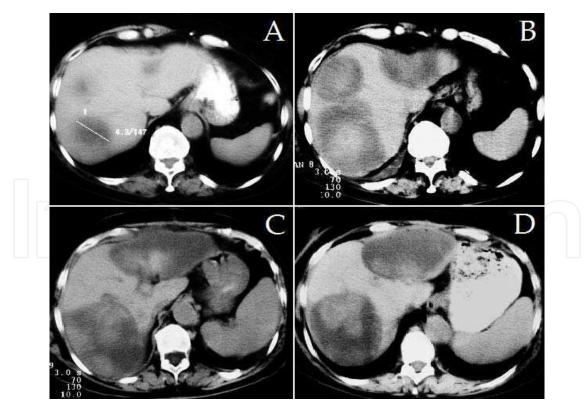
Computed tomography of a patient with colorectal liver metastases before (A) and one week after large-volume RFA (B). Posttreatment follow-up CT of a patient two weeks (C) and 6 months (D) after large volume RFA.
